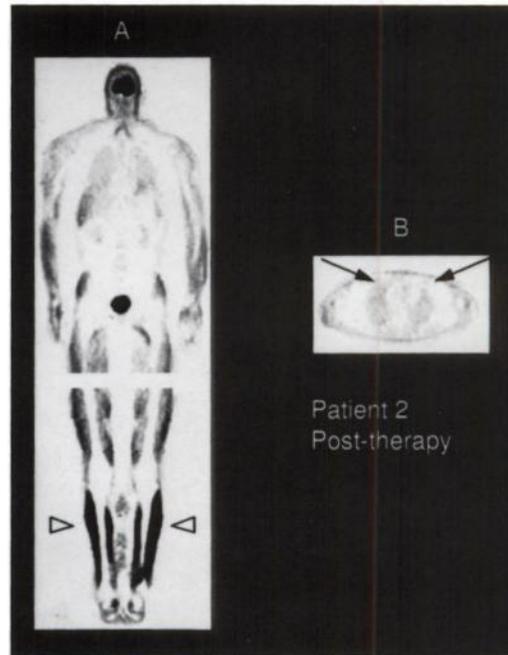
Whole-body ^{18}F FDG scan of Patient Three after steroid therapy: (A) Coronal and (B) transaxial slice through the lung hilum showing resolution of hilar uptake (arrow), but intense muscle uptake seen in the lower limbs (open arrowhead). The heart is indicated by the closed arrowhead.
